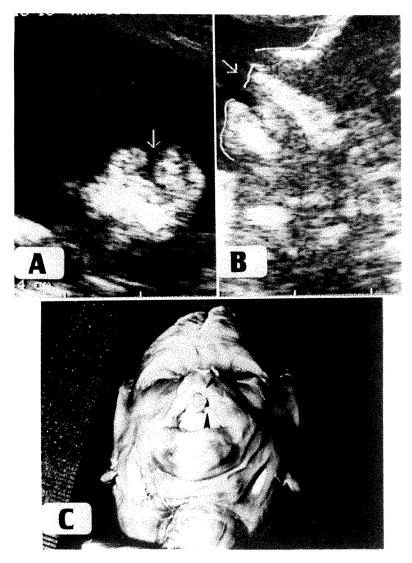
A, Tangential transvaginal ultrasonographic section of upper lip demonstrating cleft lip (arrow) in case 1. B, Sagittal left paramedian section of same fetus demonstrating relative protrusion of mandible (pseudoprognathism) caused by cleft lip. C, Cleft lip (arrows) in aborted fetus (in case 1), confirming ultrasonographic diagnosis.
